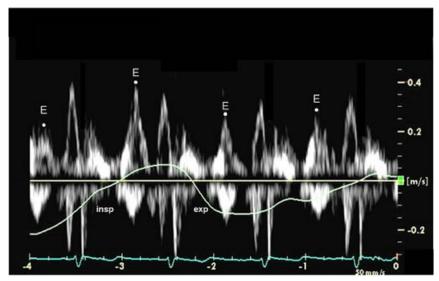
PW Doppler recording of tricuspid inflow in a patient with cardiac tamponade. Peak velocities and velocity-time integrals are low reflecting the reduced cardiac output. There is increased respiratory variation in peak E-wave inflow velocity compared with normal (white dots), with the highest value on the first beat of inspiration (insp) and the lowest values on the first beat of expiration (exp). These respiratory changes are opposite to those seen in mitral flow velocity (Figure 36). Note that percentage of respiratory variation for tricuspid inflow should be calculated as (expiration – inspiration)/expiration based on the consensus of the Writing Group.
